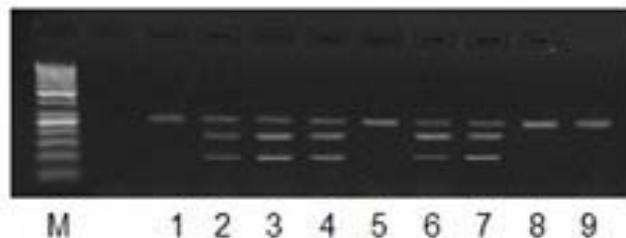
DNA electrophoresis of MTHFR C677T on agarose gel: M - DNA ladder 50 bp; 1, 5, 8 - homozygotes CC; 2- 4, 6, 7 - heterozygotes CT;
